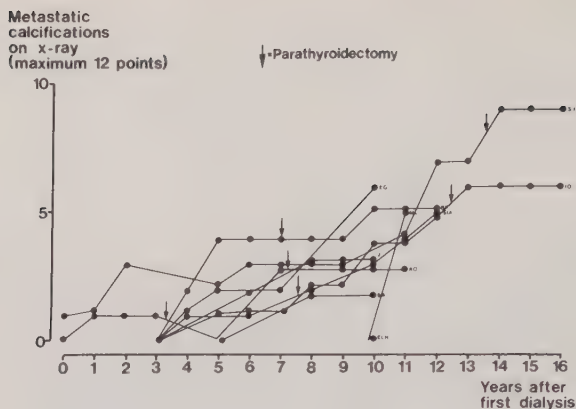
The course of metastatic calcifications on X-ray in 10 patients dialyzed for 10 years or more. Maximum 12 points.
